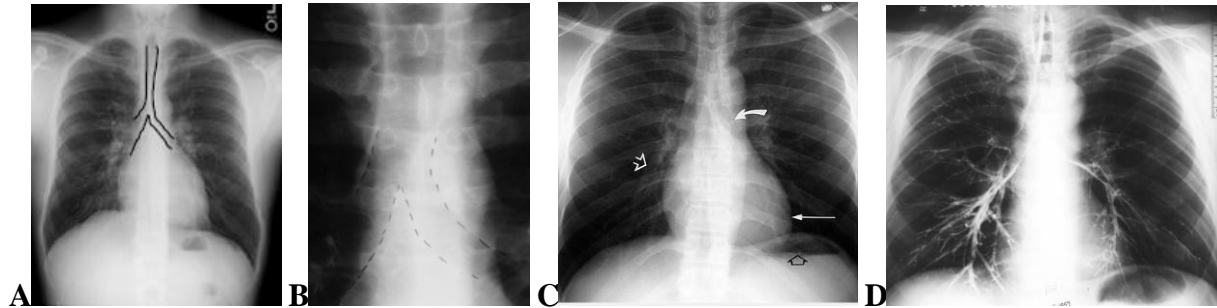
(A-B) Marked trachea, carina and main bronchi. (C) Erect PA chest radiograph. The pulmonary arteries (white open arrow) are seen in the lung because the vessels are outlined by air in alveoli. The left cardiac border (long arrow) is crisply defined by the adjacent air-filled lung. The left main bronchus (curved arrow) is seen because its air-filled lumen is surrounded by soft tissue of the mediastinum. An air-fluid level (open black arrow) in the stomach confirms the erect position of the patient during exposure of the radiograph. (D) Normal bronchogram
